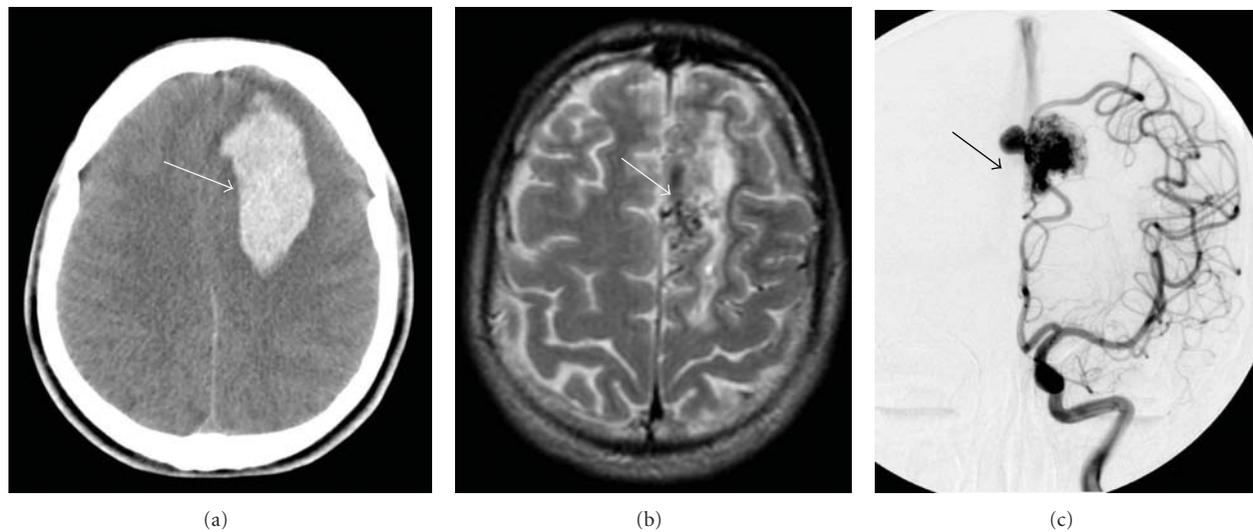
A 17-year-old male with headache, neck stiffness, and right hemiparesis. (a) Plain CT scan shows left frontal intraparenchymal hemorrhage (arrow). (b) MRI T2-weighted Turbo Spin Echo performed 4 days after surgical evacuation of hemorrhagic lesion shows the cause of bleeding: an arteriovenous malformation (arrow). (c) Intra-arterial digital subtraction angiography confirms and better evaluates the arteriovenous malformation (arrow).
